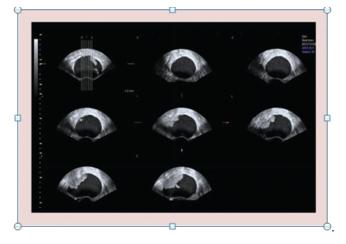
Tomographic ultrasound imaging of an ovarian malignant tumour.
